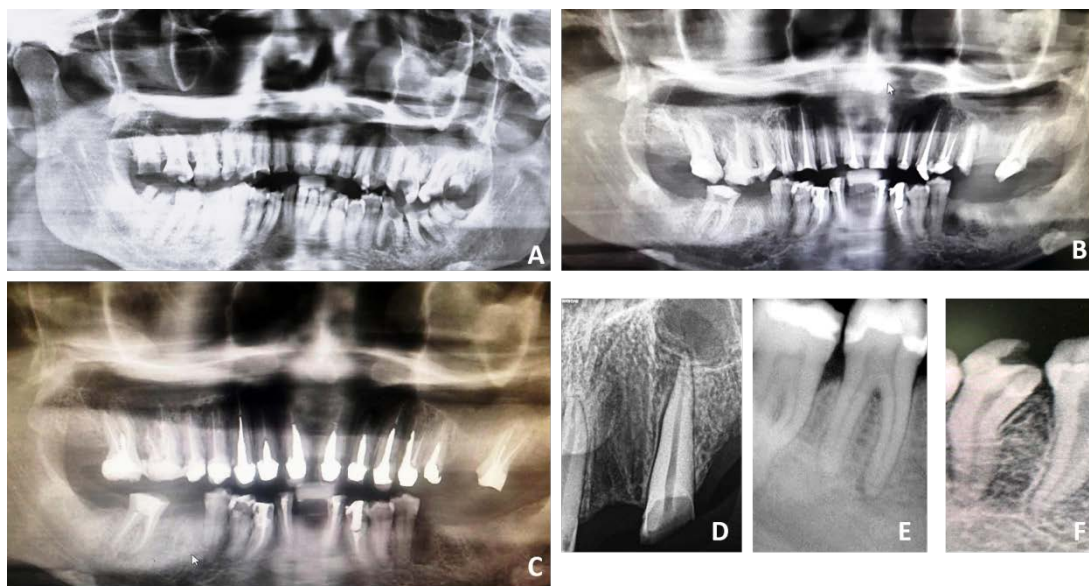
(A) Preoperative orthopantomograph showing the scale of tooth destruction (B) Orthopantomograph showing endodontic treatment of planned retained dentition (C) Orthopantomograph showing the status of foundation restoration used (D) Intra oral periapical radiograph of a tooth that was retained as a strategic treatment plan (E) Peri apical radiograph of mandibular molar with apical periodontitis (F) Radiograph showing a curved root canal
